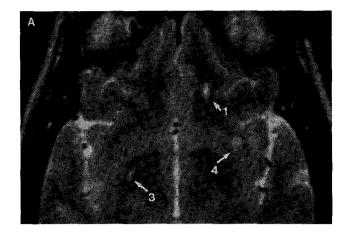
A 55-year-old MS patient with no significant olfactory dysfunction, as measured by the UPSIT. Axial T_2W MRI scan shows no obvious plaques in the inferior frontal and temporal lobe regions (A). Numerous plaques were identified in supraperiventricular regions (B).
